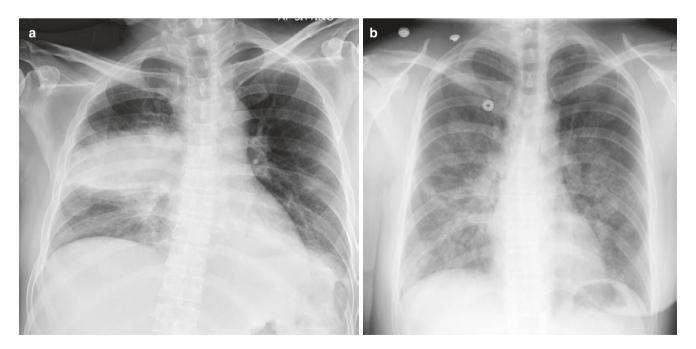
Patterns of density. (a) Frontal radiograph shows dense consolidation in the right mid-zone due to pneumonia. (b) Radiograph shows perihilar ground-glass opacities due to *Pneumocystis jirovecii* pneumonia
